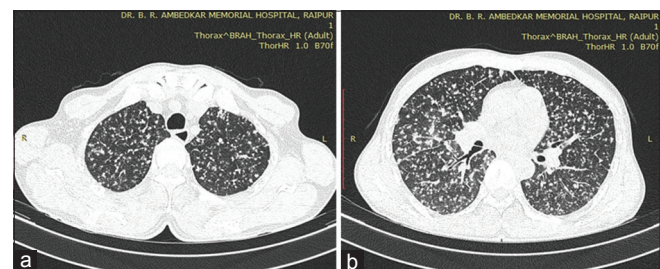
Axial high-resolution computed tomography images (a) through the upper lobes (b) subcarinal level showing miliary nodules diffusely involving bilateral lung fields. Case of miliary tuberculosis
